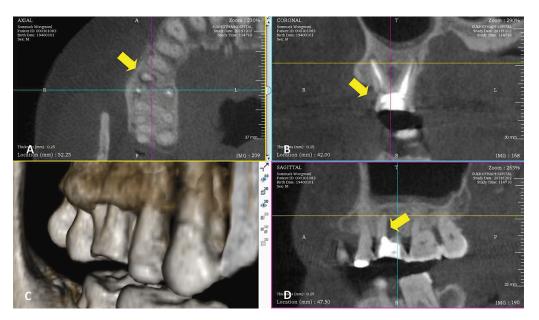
CBCT of case 2. (A) axial view, (B) coronal view, (C) reconstruction view and (D) sagittal view.
